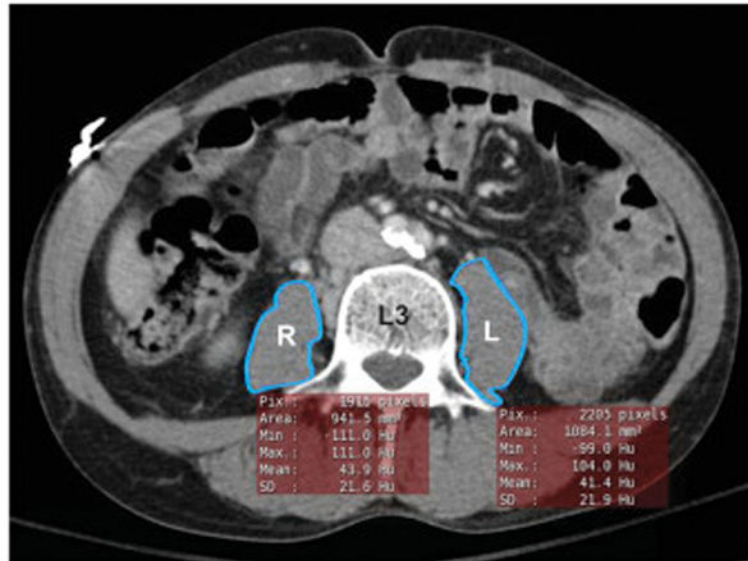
CT Psoas Muscle Area and Density Measurement
